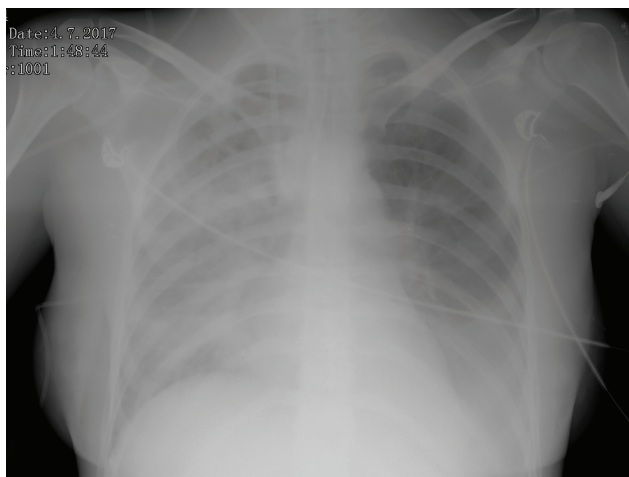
Chest X-ray demonstrating pulmonary edema.
